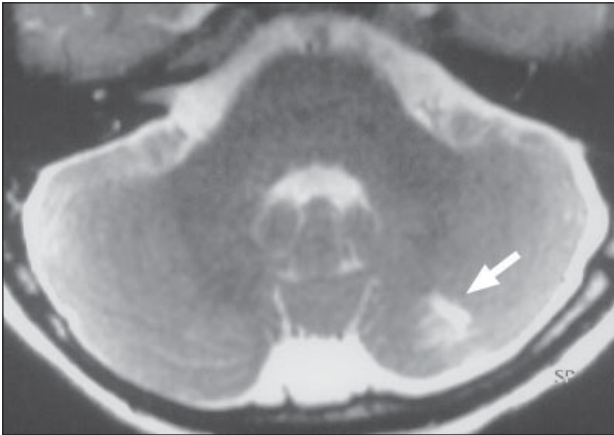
T2-weighted axial image shows infarct of left cerebellum (arrow).
